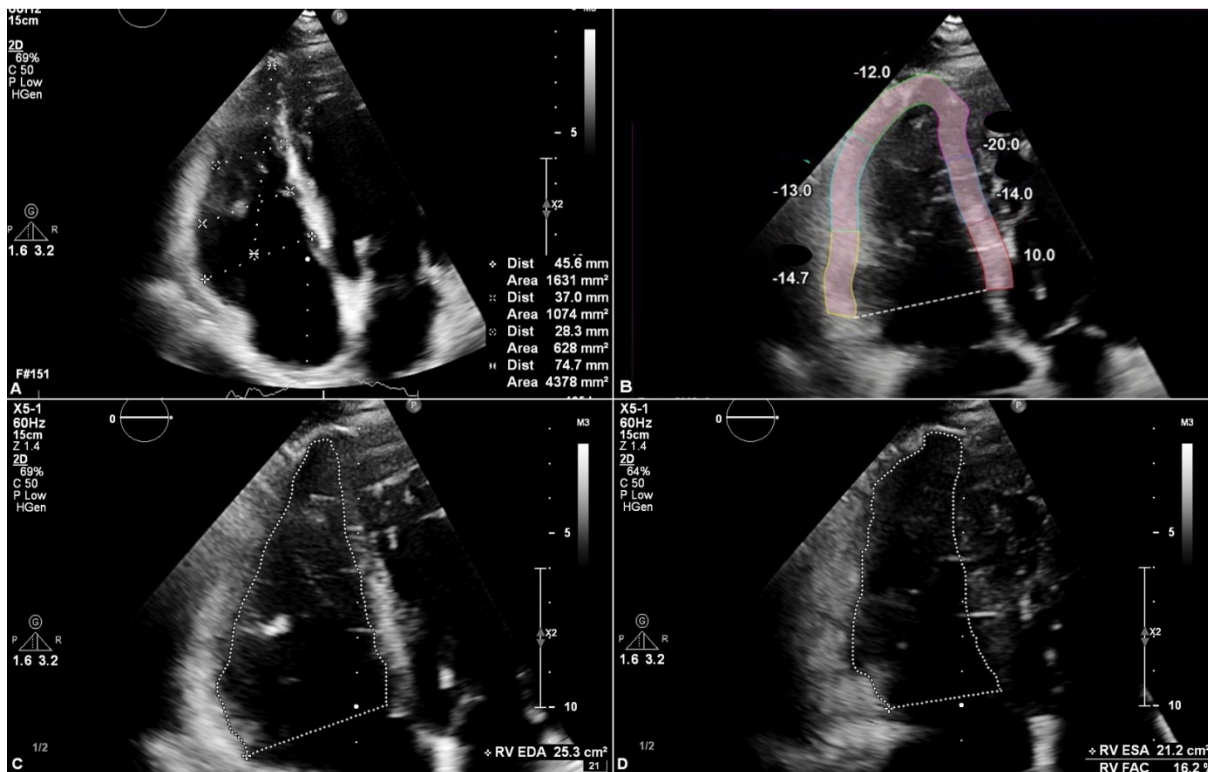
Transthoracic echocardiography: A) dimensions of the right ventricle (RV); B) the strain of the free wall of the RV (-13.3); C) right ventricular end-diastolic area; D) right ventricular end-systolic area and fractional area change (16.2%).
